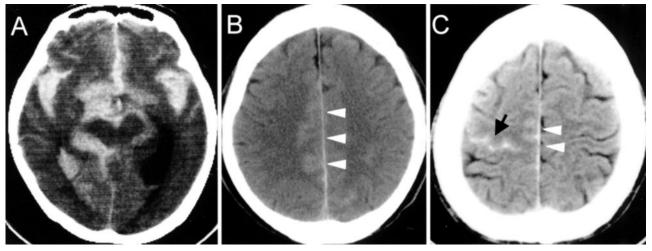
Representative CT findings in patients presenting with SAH.
